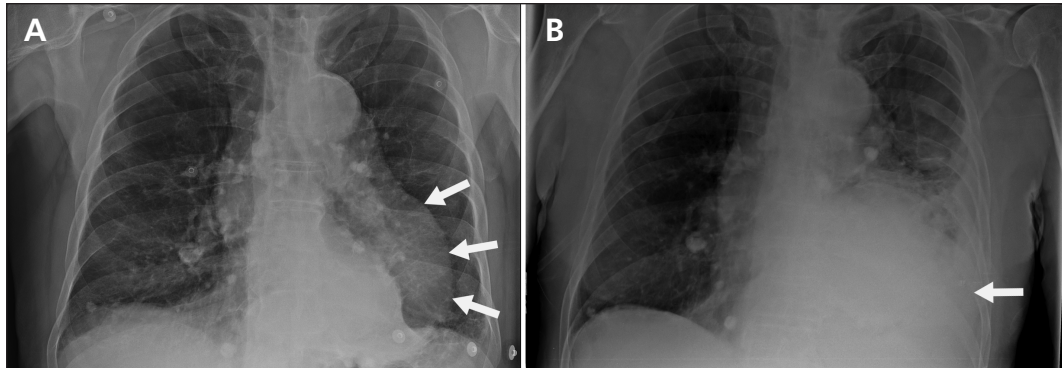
(A) Chest radiograph of a 78-year-old man obtained on admission, showing marked aortic tortuosity (arrows). (B) A chest radiograph obtained within 30 minutes of sudden-onset chest pain and shortness of breath showed a new left pleural effusion (arrow).
